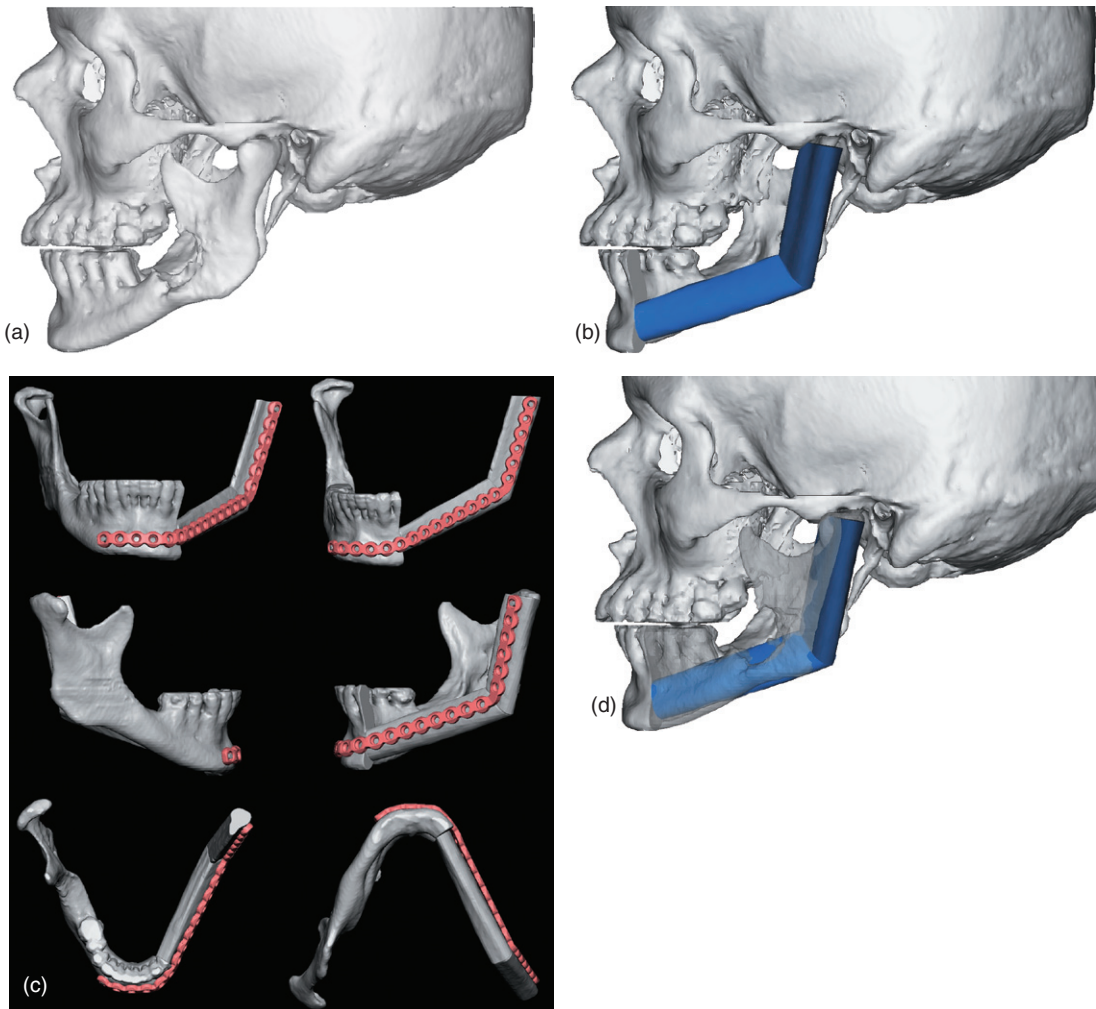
Virtual surgery planning for resection of the left mandible due to invasion by retromolar trigone SCC. (a) 3D reconstruction of the mandible. (b) Replacement by patient's left fibula from the CT scan of the patient's left lower extremity. (c) Transparency of fibula reconstruction over native mandible. (d) Case planning with reconstruction plate.
